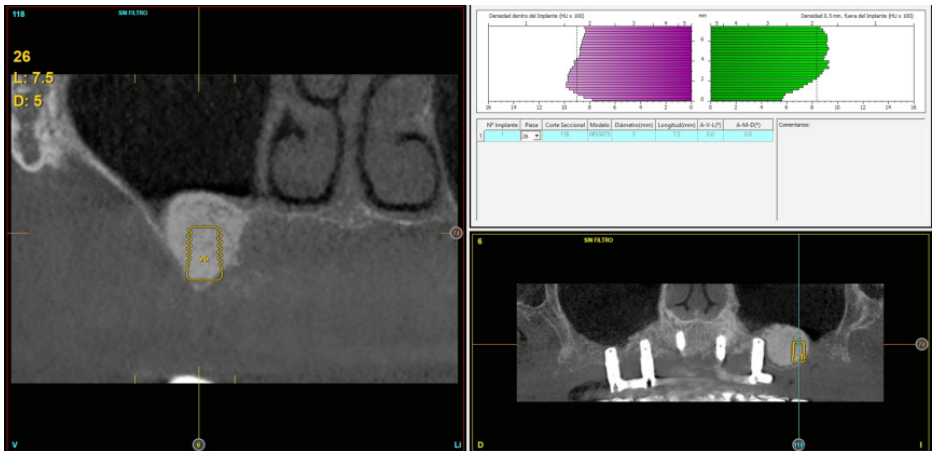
Post-sinus lift CT image.
